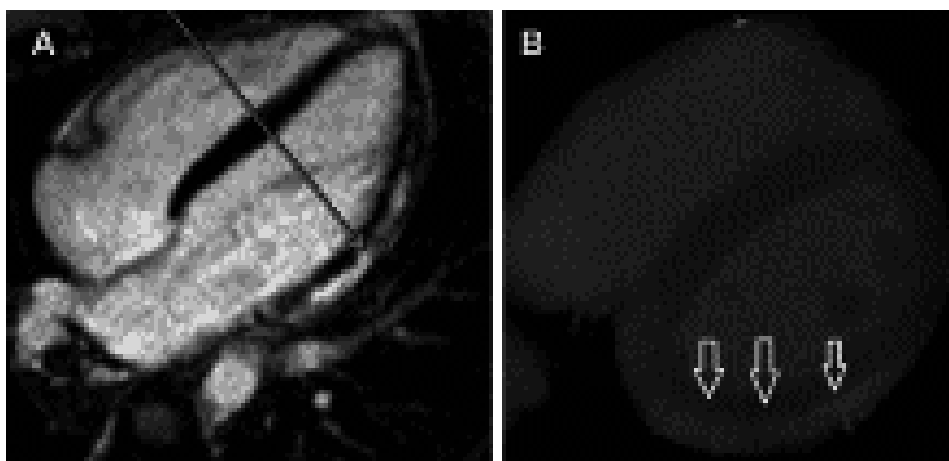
Four chamber long-axis views. (A) Cardiac magnetic gadolinium delayed enhancement showing subepicardial hyperenhancement (arrow). (B) Cardiac CT delayed enhancement (arrows). Adapted from reference 44 with permission from Elsevier.
